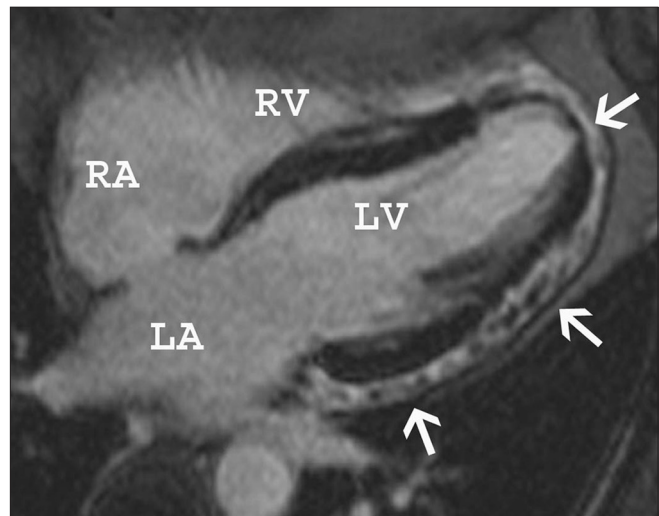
Cardiac sarcoidosis. Four-chamber delayed-enhancement magnetic resonance imaging in a patient with known sarcoidosis and heart block shows diffuse myoepicardial enhancement (arrows) in a pattern consistent with cardiac sarcoidosis
